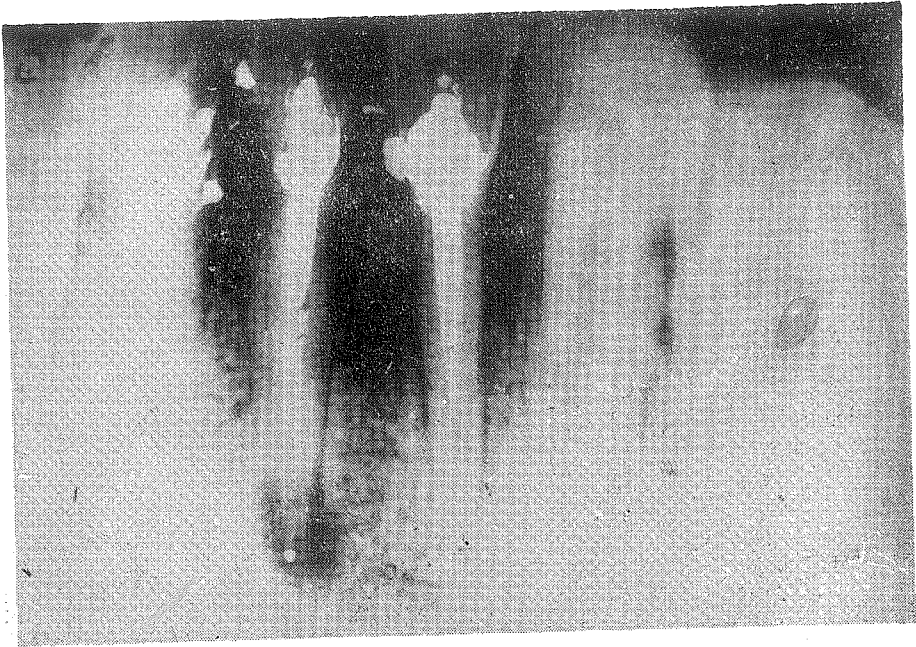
Control x-ray taken four months after the amalgam canal therapy showing the size of the process to be decreased.
